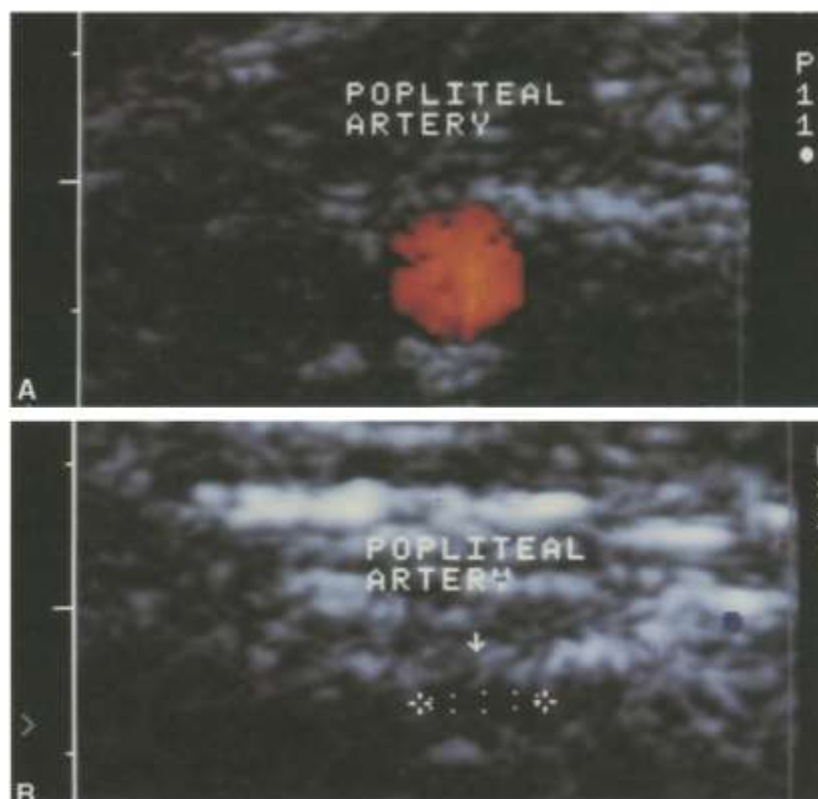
Color duplex sonography of popliteal artery (transverse section) in normal position (upper panel) and during active plantar flexion (lower panel). In normal position, color flow signal of popliteal artery is well visualized. During plantar flexion, vessel is compressed and flow signal completely disappears⁽³⁰⁾
